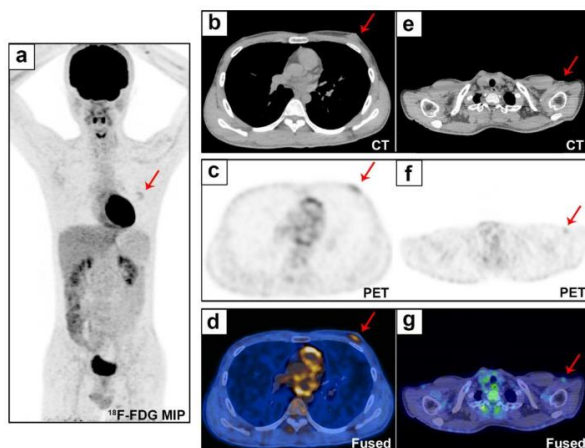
Whole-body evaluation by ^{18}F -FDG PET/CT. The ^{18}F -FDG PET/CT MIP (a) shows uptake (SUVmax 2.5) in the left breast lesion (b and d, red arrows), with a disordered tissue structure (c, red arrow). Small lymph nodes were found in the bilateral neck and bilateral axillary regions (e-g, red arrows, SUVmax 1.65). ^{18}F -FDG PET/CT: ^{18}F -fluorodeoxyglucose positron emission tomography/computed tomography; MIP: maximum intensity projection; SUVmax: maximum standardized uptake value. Image source: Li et al. (4) doi: 10.14740/jmc3790; reused under the terms of the Creative Commons Attribution Non-Commercial 4.0 International License.
